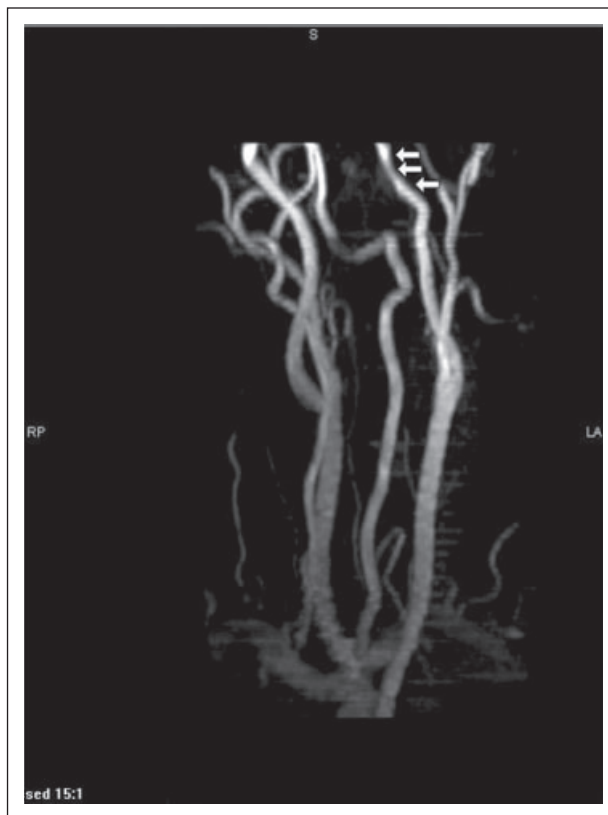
MRI image of the distal left cervical carotid artery dissection just prior to the petrous segment. MRI = magnetic resonance imaging.
